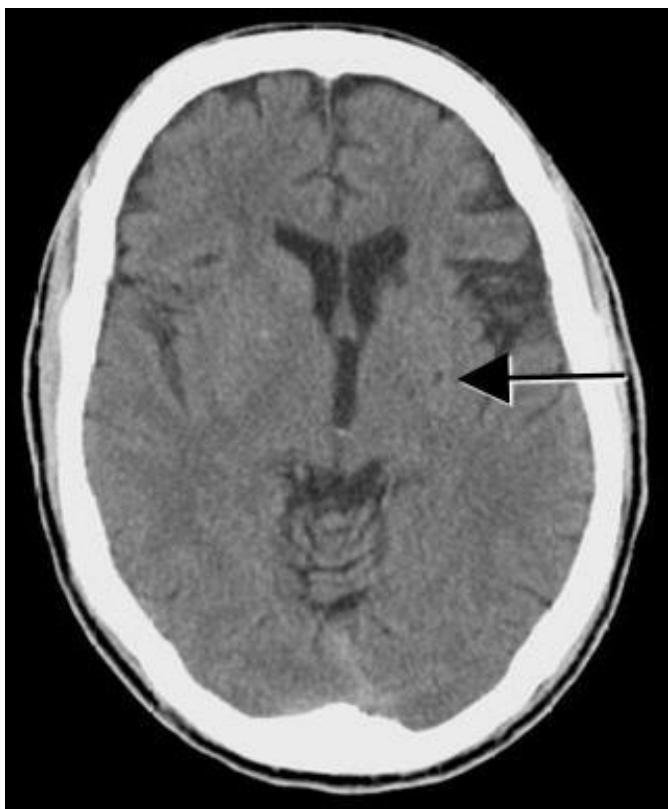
Axial CT scan of brain without contrast. Small lacunar infarct involving the left basal ganglia (arrow).
